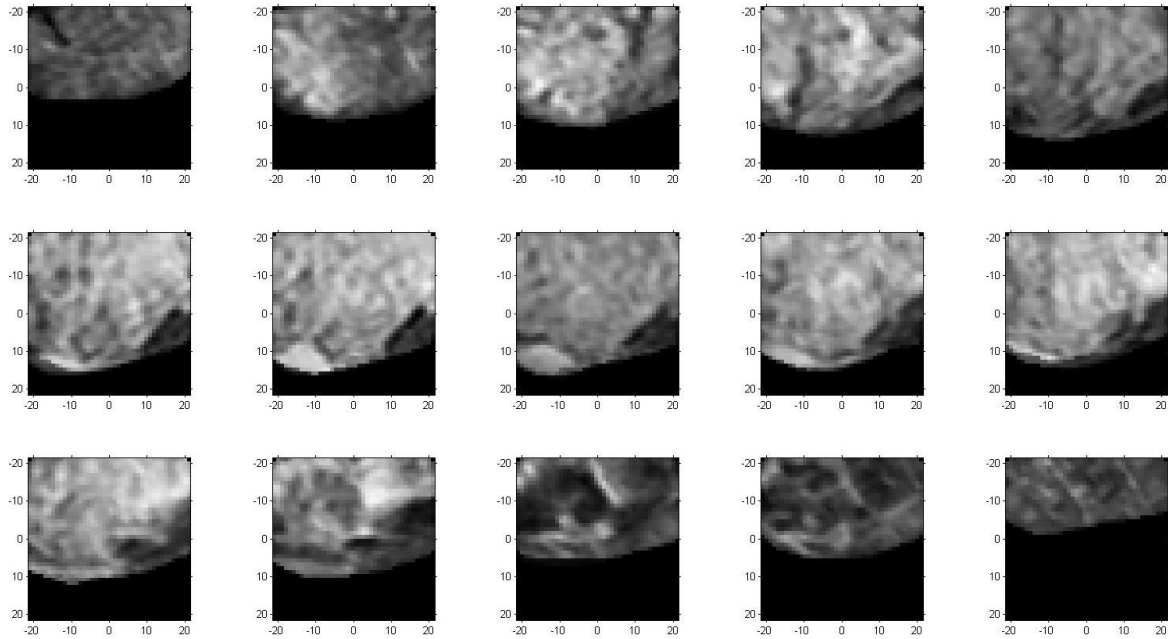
T1-weighted MR images within the volume of interest. Note that the MR images are down-sampled to the PEM resolution for image registration purpose.
